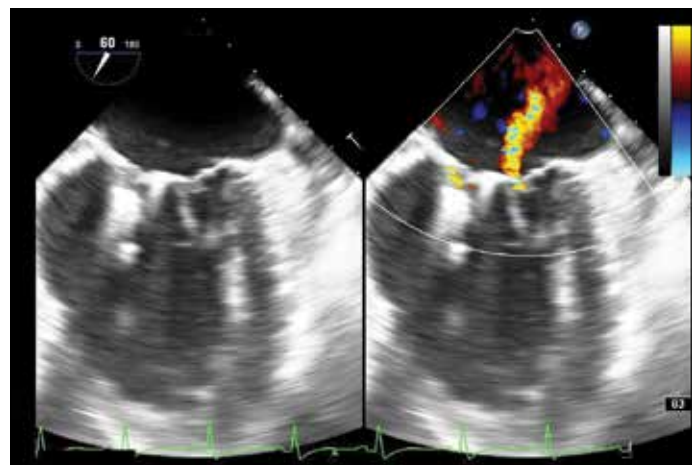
After the procedure, transesophageal echocardiography demonstrates grade I mitral regurgitation in long-axis view
